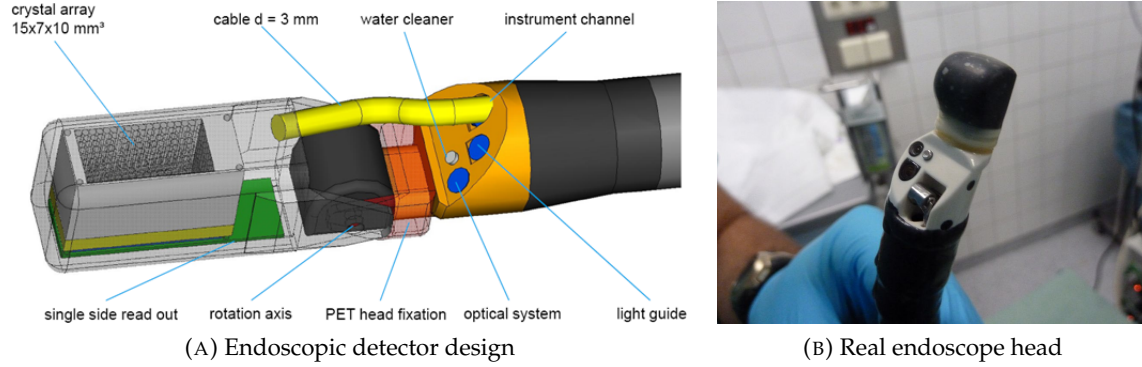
Endoscopic TOF-PET detector and ultrasound probe. 5.1a) Details of EndoTOFPET-US detector details, electromagnetic tracking sensors are not shown. Please note that the PET detector may rotate around the rotation axis, in order to pass the duodenal bulb. 5.1b) Close-up picture of Olympus GF UTC140-AL5 endoscopic ultrasound probe. Images courtesy of Karsten Gadow.
